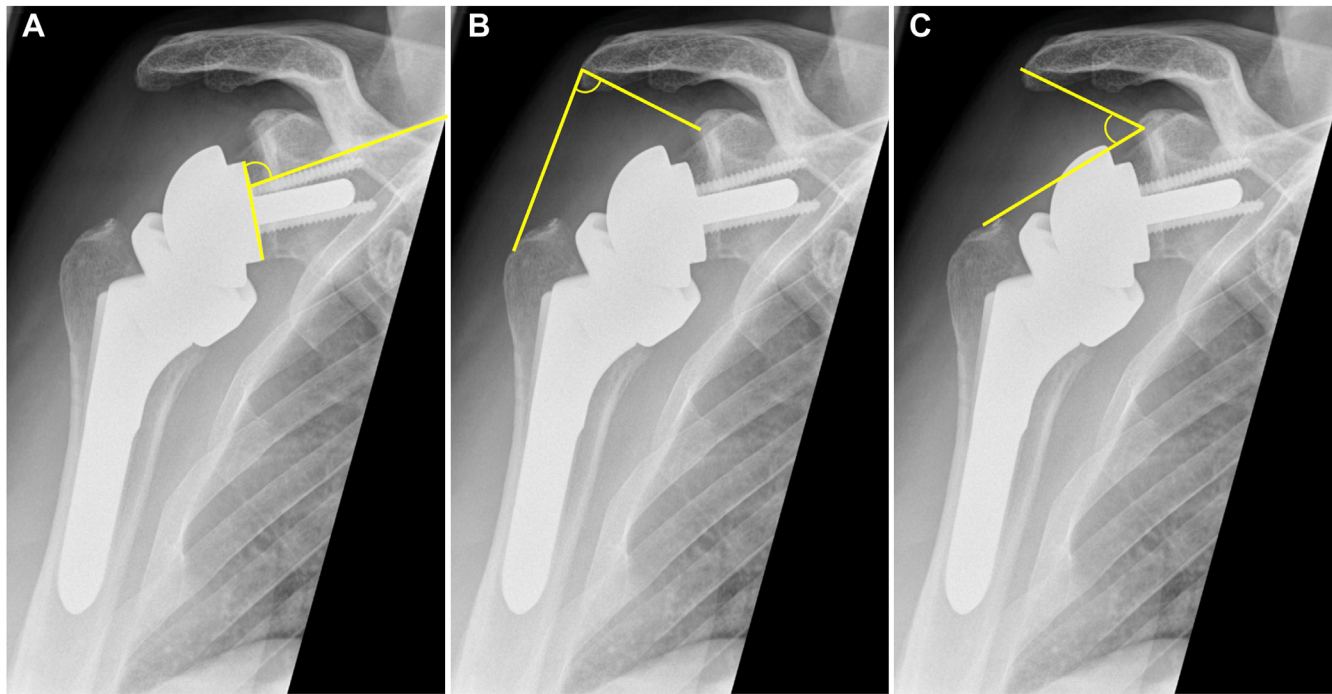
Radiographic measurements. (A) The inclination of the glenoid baseplate (reverse shoulder angle),⁶ (B) the lateralization shoulder angle, and (C) the distalization shoulder angle.⁷
